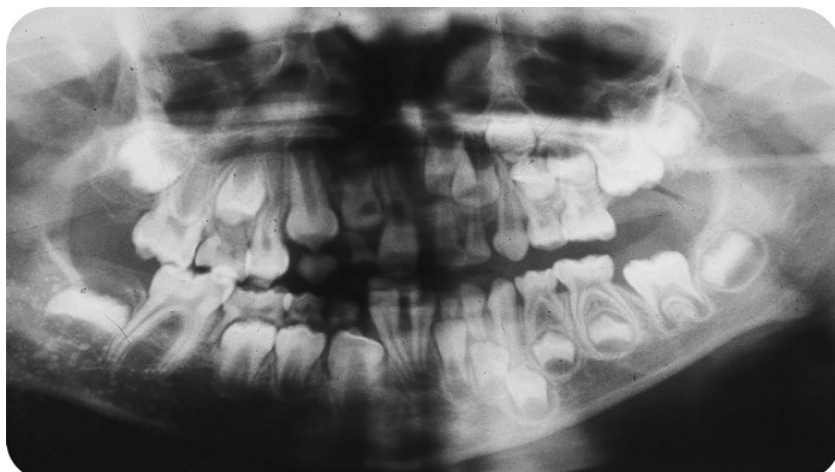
Panoramic radiograph of the girl at eight years. The differences in eruption timing between the affected side and the non-affected side can stretch by four years.
